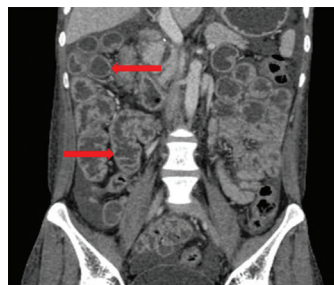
Contrast-enhanced computed tomography scan of abdomen showing jejunoileal folds pattern reversal: Featureless jejunal loops (upper red arrow) and increased mucosal folds in the ileal loops (lower red arrow).
